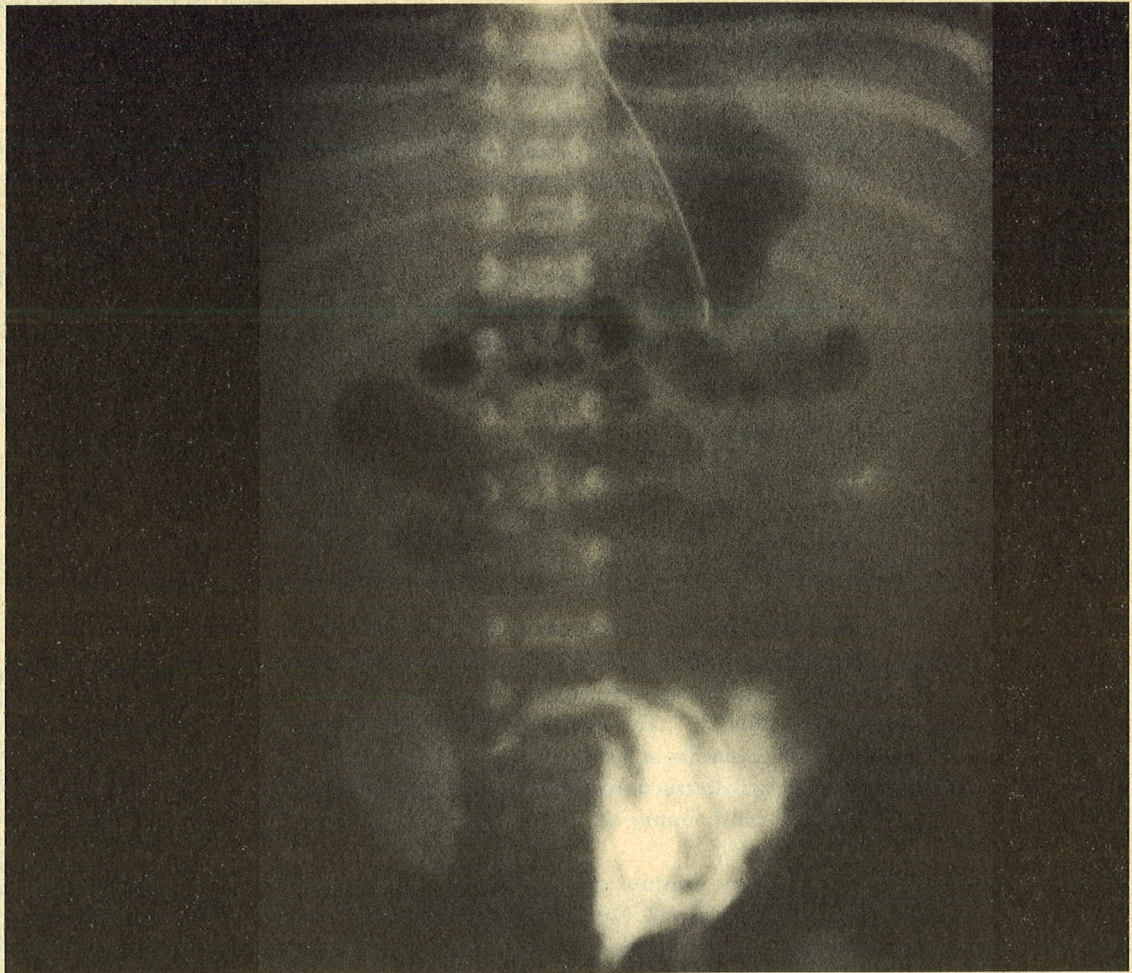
Plain abdominal radiograph
